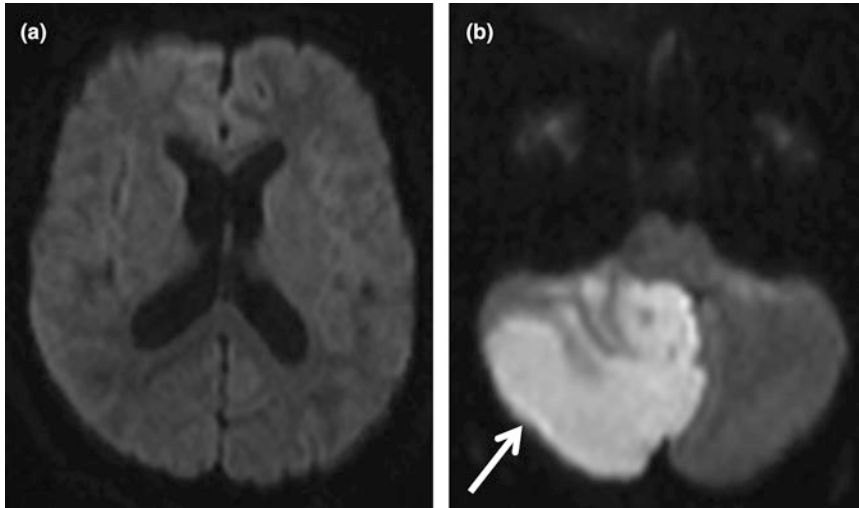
Two selected images from the DWI sequence of an MRI performed for a patient with acute onset vertigo, vomiting and loss of balance. Image a shows no evidence of diffusion restriction in the middle cerebral artery territories. In image b there is a large area of diffusion restriction in the right cerebellar lobe (high signal/bright area) consistent with an acute right-sided posterior circulation infarction
